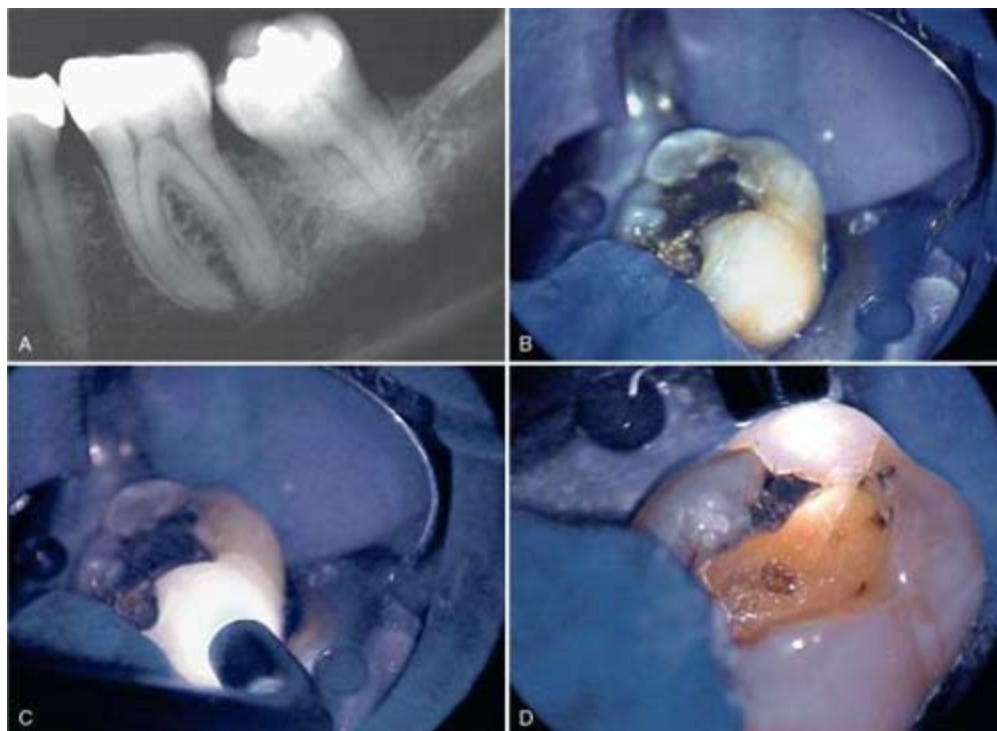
Sometimes there is no clear indication of why a tooth is symptomatic. This radiograph shows a mandibular second molar with a moderately deep restoration (A); the pulp tests nonvital. Without any transillumination, a fracture cannot be detected (B). However, by placing a high-intensity light source on the tooth surface, a root fracture can be observed on the buccal surface (C) and the distal-lingual surface (D).
